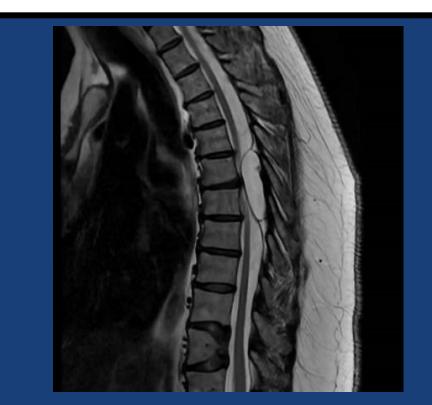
Sagittal T2 MRI of the Thoracic spine demonstrating a 4.3 x 1.4 x 2.0 cm arachnoid cyst at the T5-7 levels, resulting in cord compression and associated cord edema. The cyst extends into and effaces the left T6-7 and T7-8 neural foramina.
